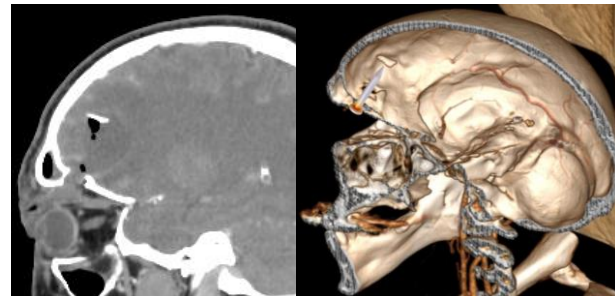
Left - Cranial CT scan demonstrating a comminuted and displaced fracture of the right orbital roof. Associated findings include a small right frontal intraparenchymal pneumocephalus and limited subarachnoid hemorrhage. Right - 3D reconstruction demonstrating the trajectory of the metallic object and the migrated bone fragment secondary to the fracture.
